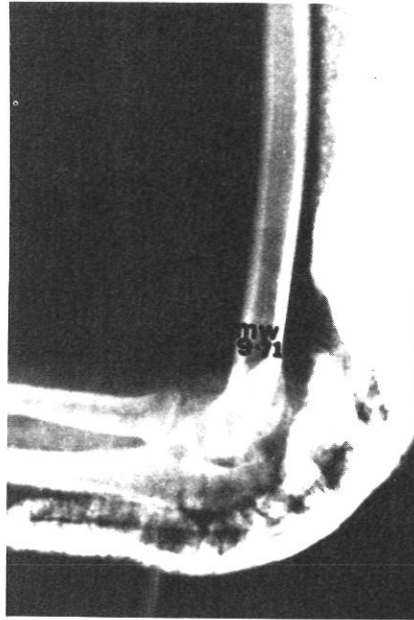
Post-reduction roentgenogram shows dislocation of left elbow with posterior splint applied. Note that capitellum appears to articulate with radial head.
